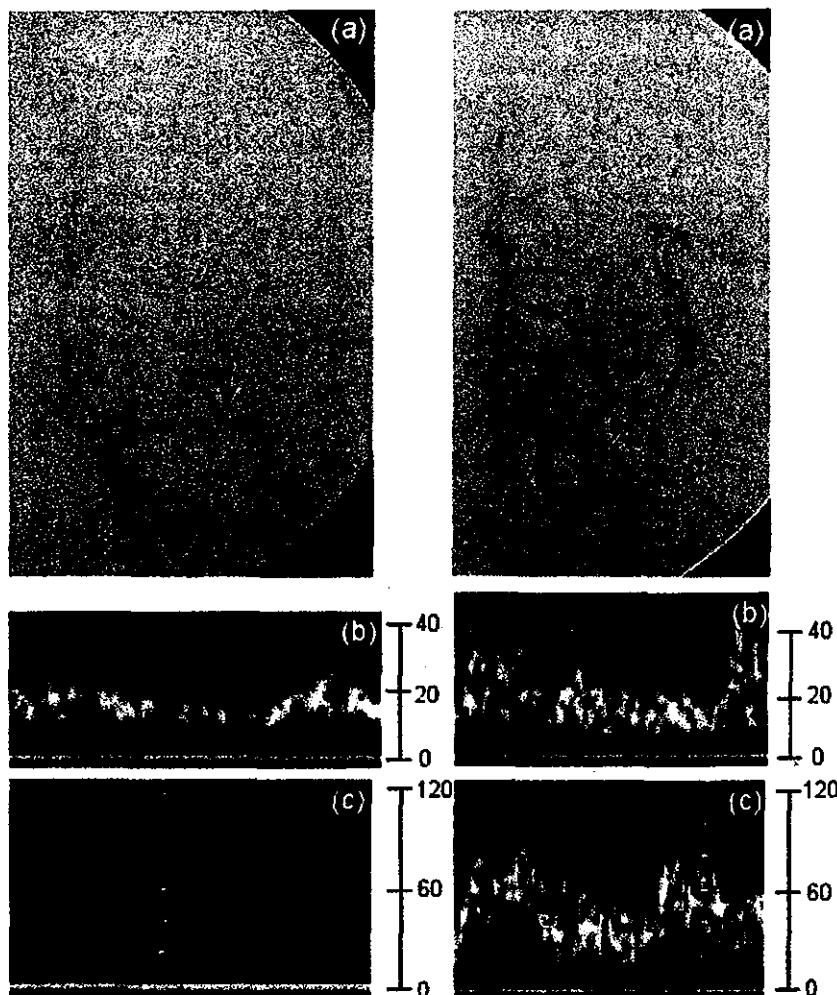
Left anteroposterior carotid angiograms in representative cases evaluated with cerebral angiography and TCCS. Y axis is represented blood flow velocity (cm/s). Left image shows occlusion of the horizontal portion of the left MCA (a). Occlusion site overlies the external carotid artery branch. Doppler waveforms of the left (b) and right (c) MCAs show EDVs of 14.5 and 49.9 cm/s, respectively. Right image shows occlusion of the branch in the left MCA (a). Doppler waveforms of the left (b) and right (c) MCAs show EDVs of 18.2 and 44.6 cm/s, respectively.
